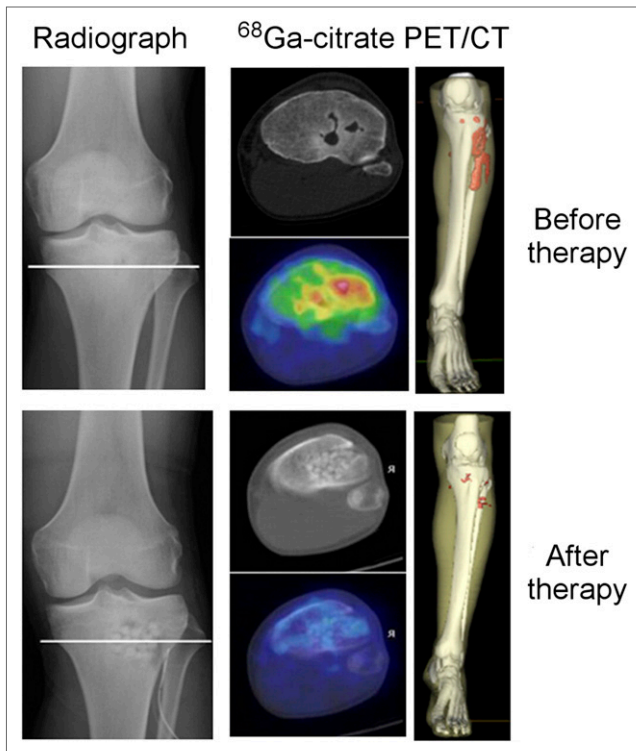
Comparison of pre- and posttreatment ^{68}Ga -citrate PET/CT scans in patient with acute osteomyelitis. Pretreatment scan showed increased radiotracer uptake involving proximal tibia. Posttreatment scan showed no significant uptake, representing complete response to treatment. (Reprinted from (13).)
